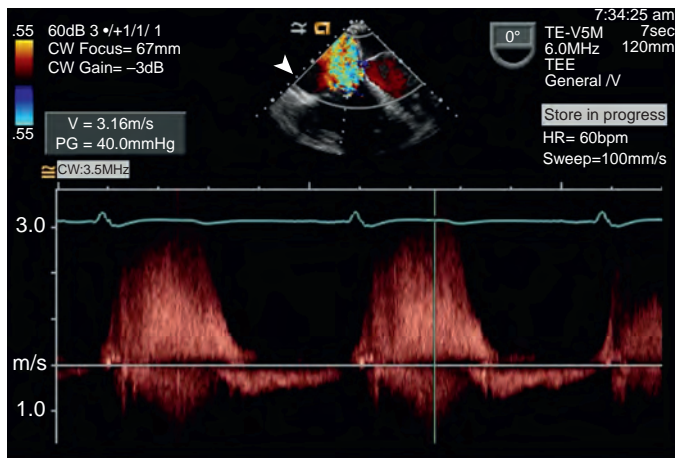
A continuous-wave (CW) Doppler used to evaluate the peak regurgitation velocity yields an estimate of pulmonary artery systolic pressure. HR, Heart rate.
